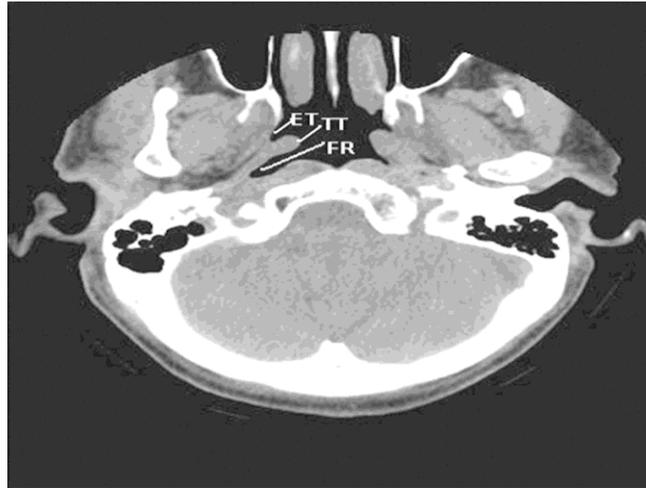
Axial computed tomography scan showing the relationship between the Eustachian Tube (ET), Torus Tubarius (TT), and Fossa of Rosenmuller (FR) [4]
